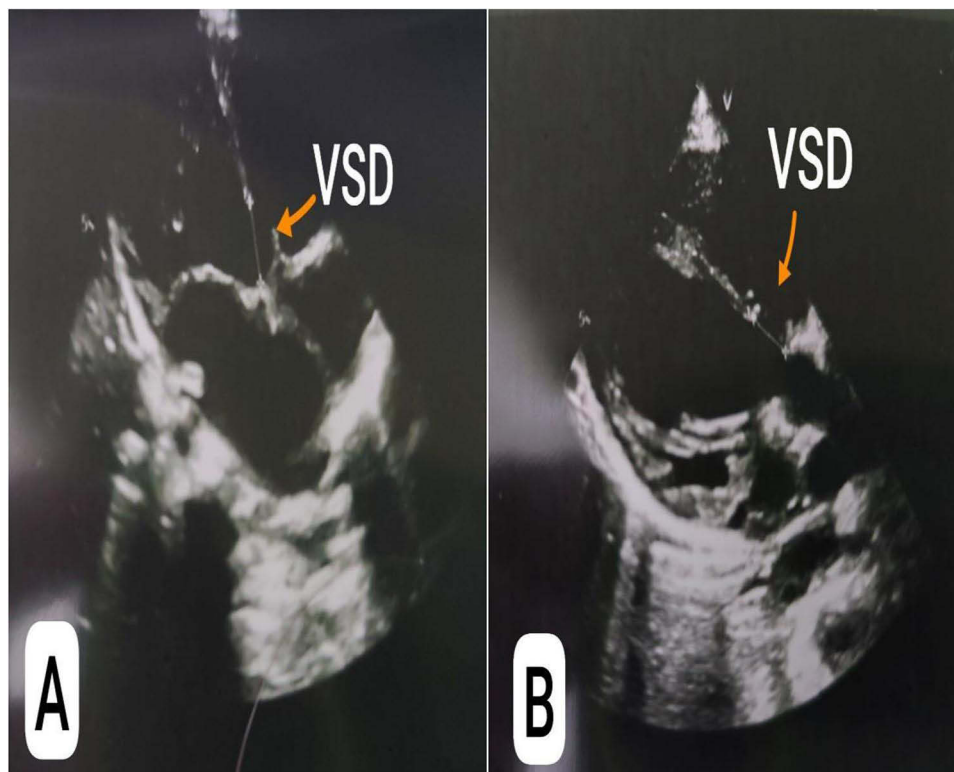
(A and B) A two-dimensional echocardiogram demonstrated a large membranous VSD, along with severe pulmonary hypertension and a closed ductus arteriosus.
